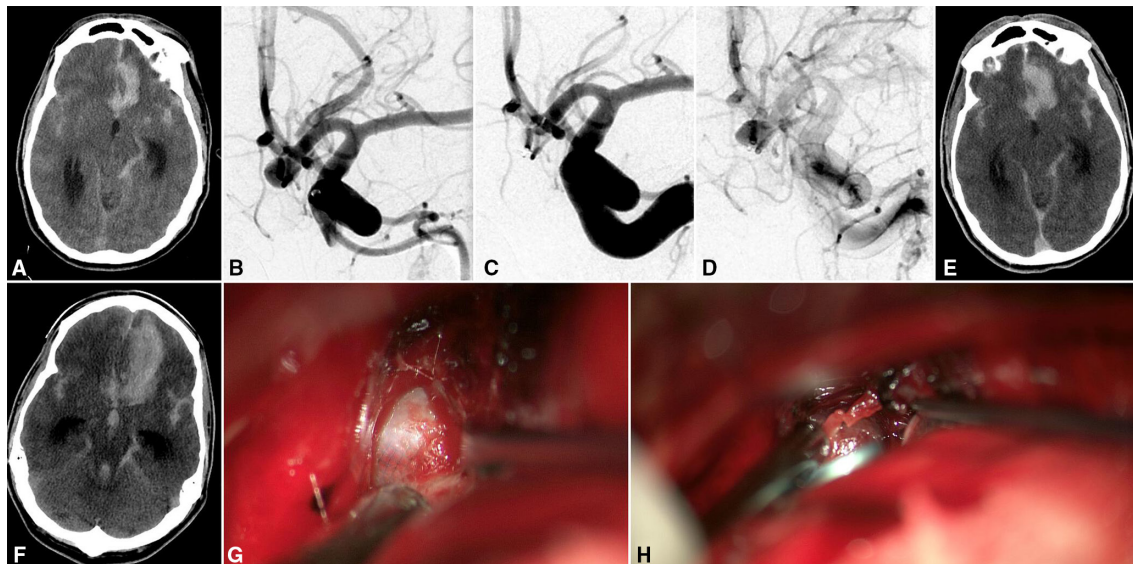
Non-contrast CT on arrival to our hospital demonstrated subarachnoid hemorrhage and development of a new left frontal intraparenchymal hemorrhage, consistent with aneurysm rebleed (A). Digital subtraction angiography working view of a 6 mm anterior communicating artery aneurysm filling via a near obligate left A1 (B). Digital subtraction angiography post WEB deployment in working views (C, early arterial phase; D, late arterial phase). CT post device deployment demonstrates a stable subarachnoid hemorrhage and left frontal hematoma (E). After 4 hours, after an acute IntraCranial Pressure (ICP) spike, an interval CT scan demonstrates an enlarged frontal hematoma and new third ventricular blood (F). Intraoperative view demonstrates the WEB device in the aneurysm (G); no uncovered alternative rupture site could be identified. Postclipping intraoperative view (H).
